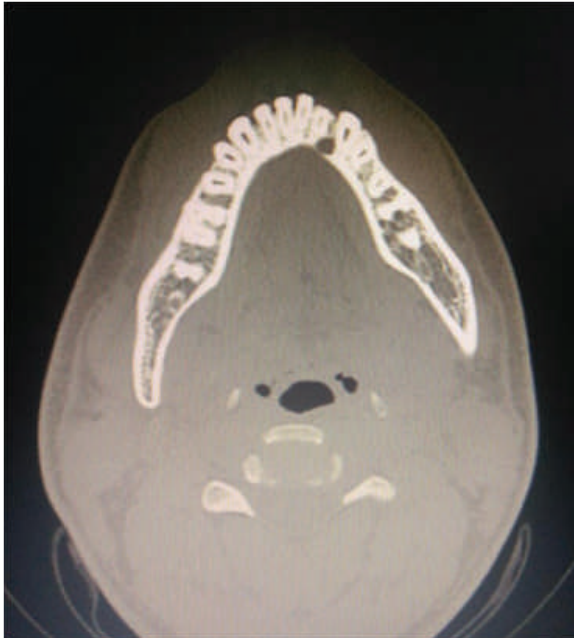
CT axial section showing lingual cortex involvement at the superior surface
